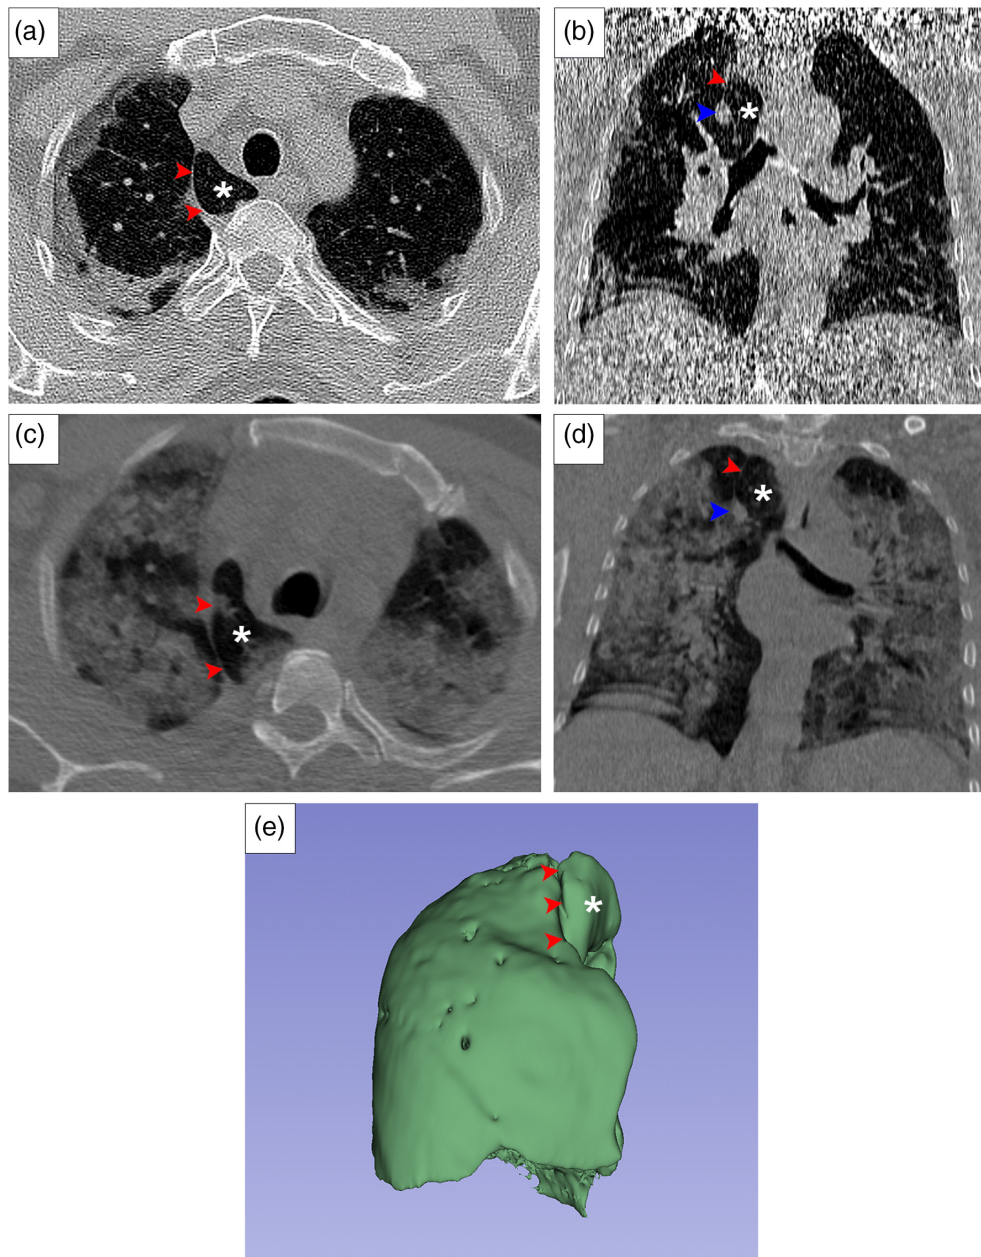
Axial (A, C) and coronal (B, D) CT images showing the presence of azygos lobe without (A, B), and with (C, D), COVID-19 pathology. The last panel (E) demonstrates the 3D reconstruction of an AL. The AL is indicated by asterisks. Red arrowheads indicate the azygos fissure while the blue arrowhead indicates the azygos vein. An interactive 3D file is available in the supporting information
